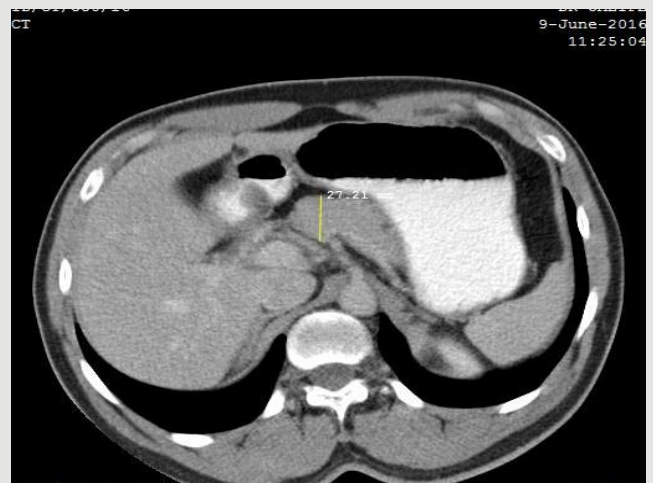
Axial CT Image of the abdomen of an adult male demonstrating the AP measurement of the head of pancreas
